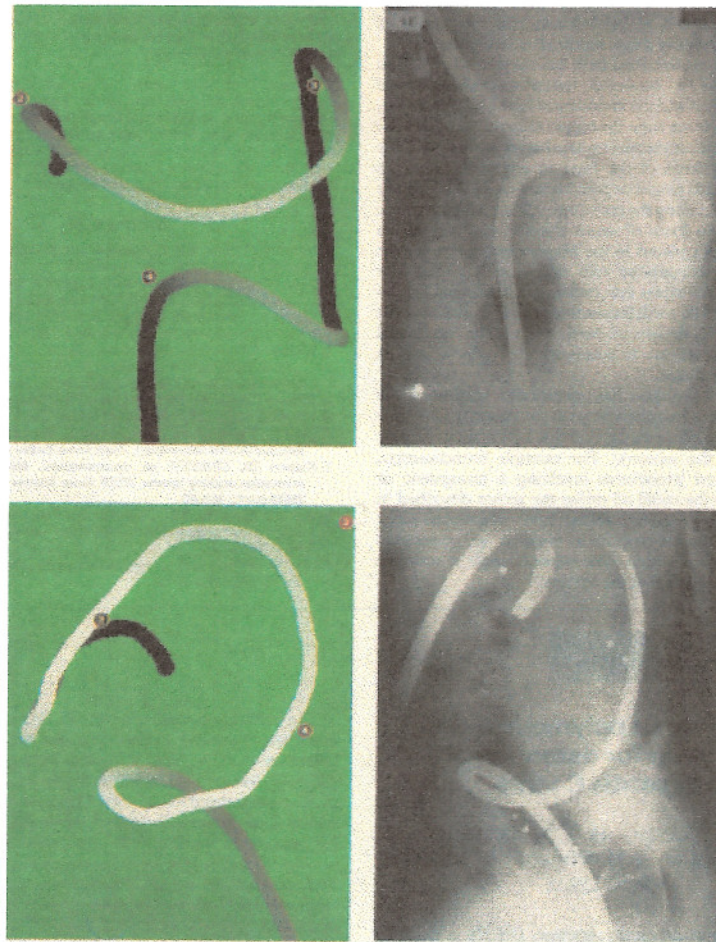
Comparison between images obtained using the system and x-ray images.
